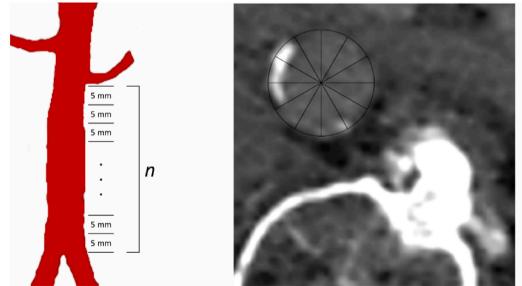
(A) Flow-chart presenting TuFIAS registers aneurysm- and control patients selection and exclusion together with ACI measurements. (B) Aortic calcification index measurement method. Left panel = number of slices 5 mm apart (=n), right panel = individual CT slice, 12-part pie-chart represents template which is used to estimate degree of calcification.
